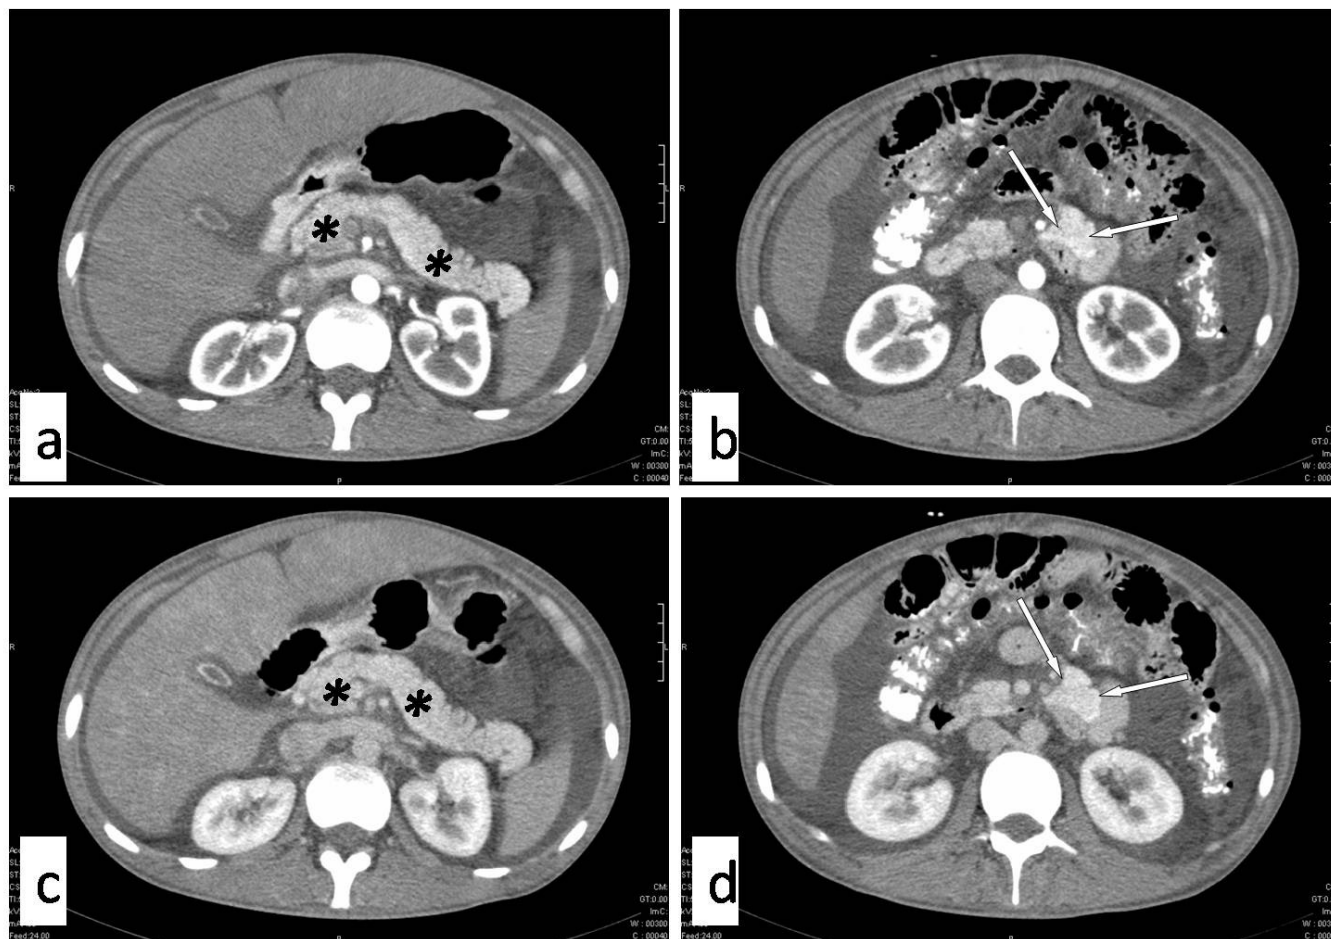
Biphase contrast enhanced CT axial images in arterial (a and b) and venous phase (c and d) showing homogeneously enhancing soft tissue in the mesentery (white arrows) having attenuation and enhancing pattern similar to pancreas (asterix).
